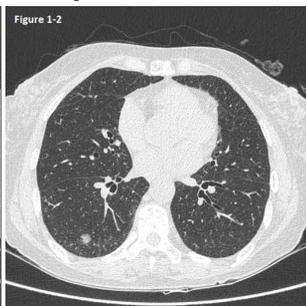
The PET-CT showed a GGO nodule in RLL with mild hypermetabolism
